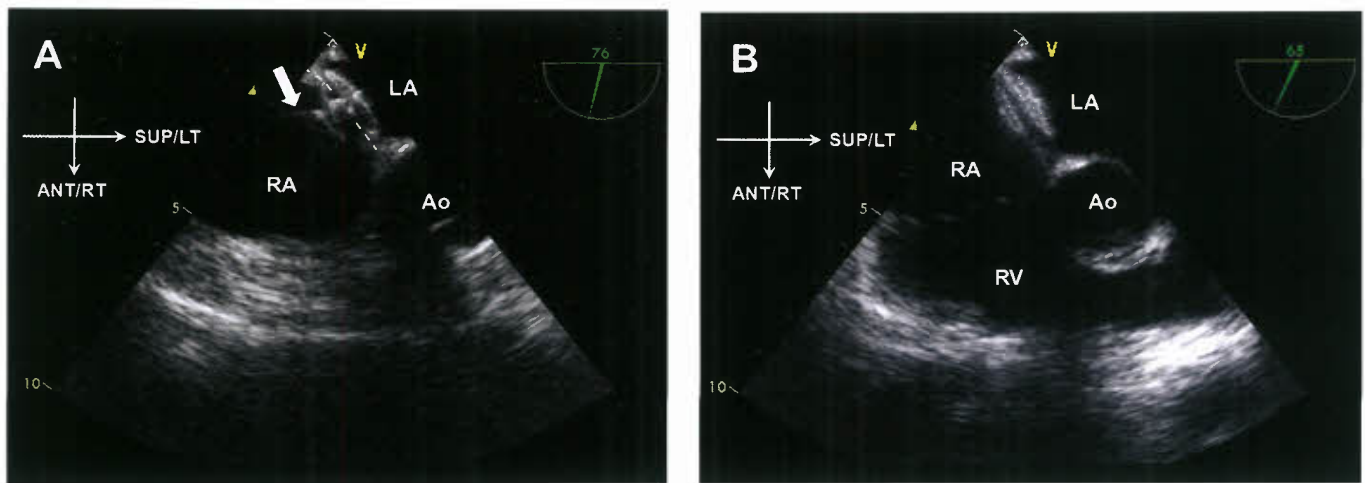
Transesophageal imaging during device occlusion of a secundum atrial septal defect (ASD). In panel A, the ASD device is seen straddling the ASD. Rim tissue (*dotted lines*) can be seen between both left atrial (LA) and right atrial (RA) discs. The device has not been released from the guidewire (*white arrow*). In panel B, the device has been fully deployed, and now sits flush against the atrial septum. ANT, anterior; Ao, aorta; LT, left; RT, right; RV, right ventricle; SUP, superior.
